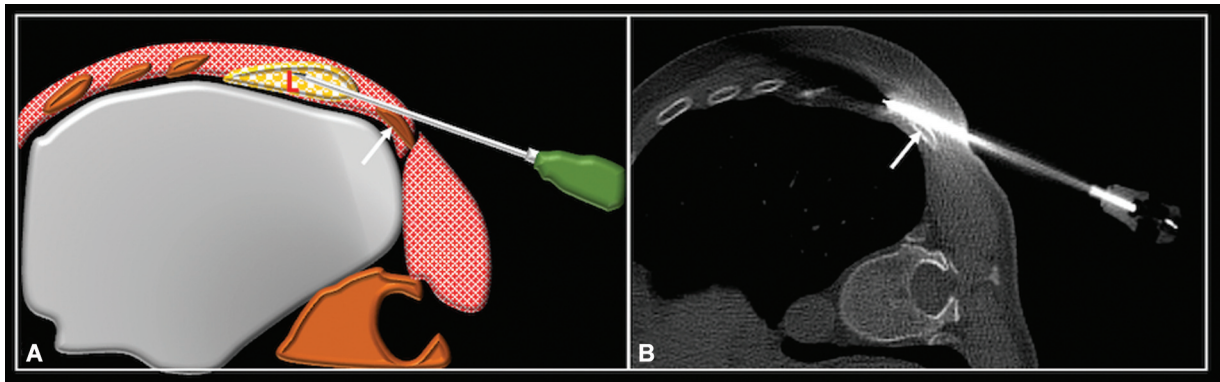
Axial computed tomography showing needle with trocar in the rib lesion (A) using the adjacent rib as a piggyback (arrow). The trocar has been removed and needle advanced into the lesion (B).
